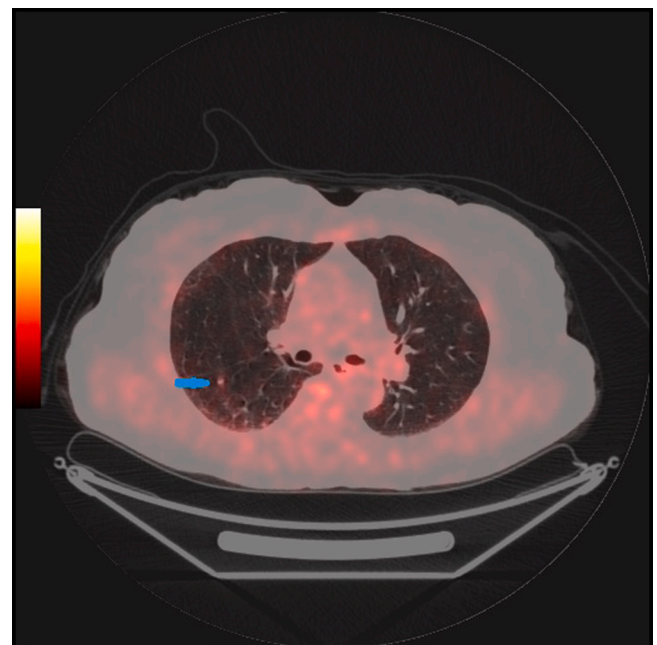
76 year old female with history of moderately differentiated adenocarcinoma of the colon and was found to have a new indeterminate/ equivocal/ suspicious lung nodule on follow-up anatomic imaging with the acquired FDG PET/CT showing increased uptake in the nodule that resolved on follow up scans and was considered a false positive lung nodule likely related to inflammatory/ infectious etiology.
